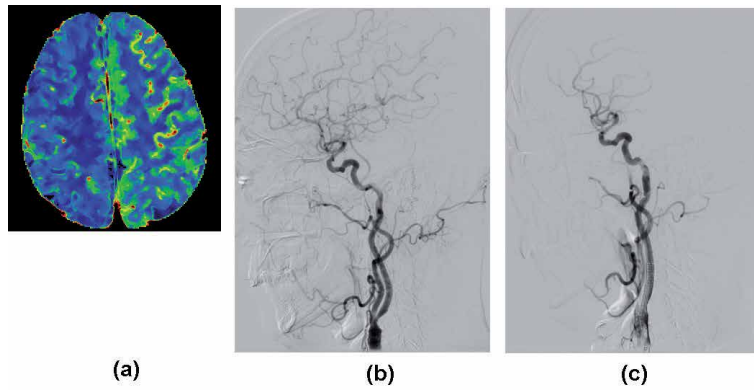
A 79-year-old man presented with dizziness. a, CT perfusion image showing the low perfusion of the right cerebral hemisphere. b, right carotid artery angiogram showing the severe stenosis of the internal carotid artery. c, right carotid artery angiogram showing the stenosis was treated with angioplasty and stenting.
